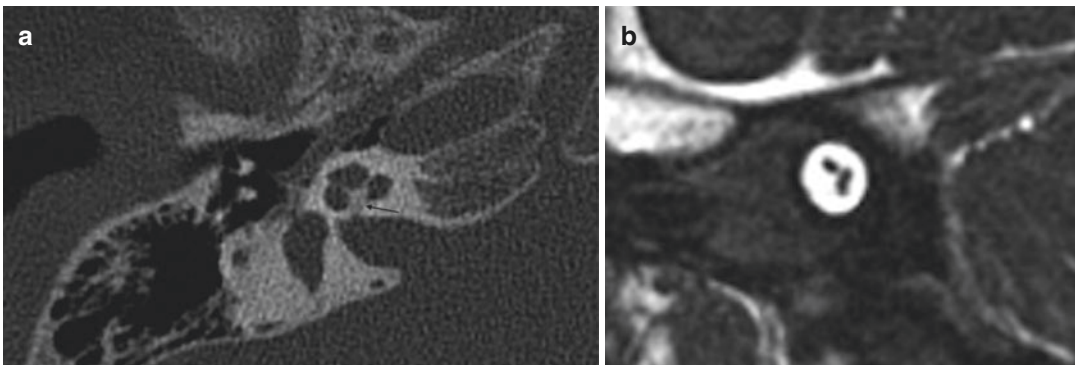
Axial temporal bone CT (a) and sagittal oblique 3D-DRIVE image (b) of a patient with bilateral congenital severe SNHL. The CT image of the right ear reveals
